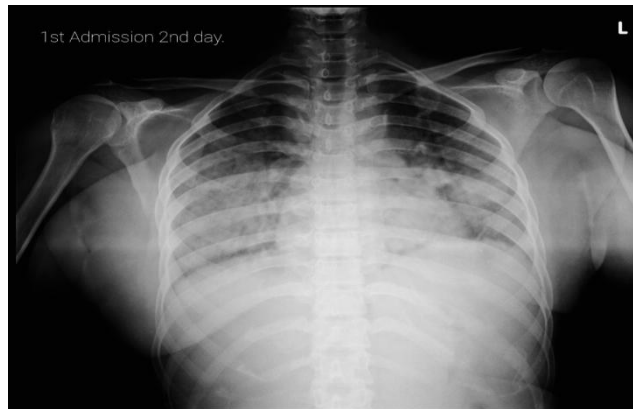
Chest X-ray showing bilateral homogeneous opacities suggestive of Adult respiratory distress syndrome (ARDS)
